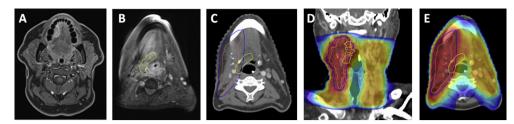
Example of type B recurrence at the primary site (peripheral, high dose). Patient with pT2pN2bM0 squamous cell carcinoma of the right lateral tongue. Treatment was with partial glossectomy, free flap reconstruction and right selective neck dissection followed by adjuvant chemoradiotherapy to the primary site and bilateral neck 66 Gy in 33 fractions. Four months after radiotherapy there was local recurrence posterior to the flap (biopsy proven). (A) Preoperative magnetic resonance imaging (MRI; T1 fat saturation with gadolinium enhancement) showing tumour on the right lateral tongue. (B) Recurrence posterior to the flap contoured on recurrence MRI deformed to the planning computed tomography (CT) (yellow). (C) Recurrence on planning CT (contoured on MRI deformably co-registered to planning CT) showing the clinical target volume (CTV; pink) and planning target volume (PTV; blue). (D) Coronal view of planning CT showing CTV (pink), PTV (blue), recurrence (yellow), centroid of recurrence (green), together with a colourwash of dosimetry, showing the centroid of recurrence within the high-dose volume. (E) Axial slice planning CT near the inferior part of the recurrence showing part of the recurrence (yellow) extending out of the high-dose volume.
